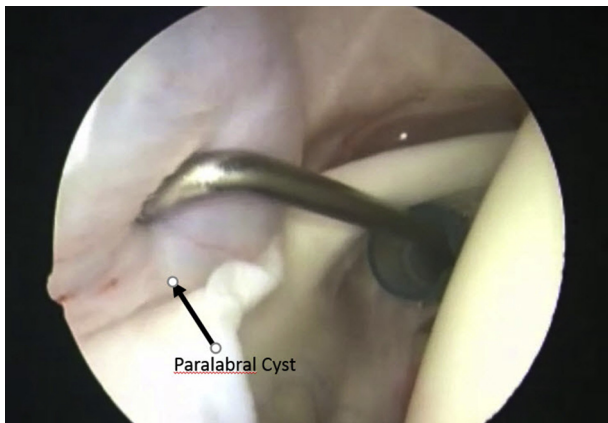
With visualization through the posterior portal with a 30° arthroscope with the patient in the beach-chair position, the probe is inserted through the anterior working portal through the rotator interval. In this case, the capsular tissue just posterior to the biceps origin is probed and manipulated to confirm the location of the paralabral cyst (arrow) just medial to the capsule. The location is determined from the reference point found on magnetic resonance imaging. Here, the probe can be seen to compress a fluid-filled mass just deep to the capsular tissue, which shows the most lateral margin of a posterior-superior paralabral cyst. This confirmation under direct visualization allows the surgeon to establish the location of the limited capsulectomy that is to be made to gain access to the cyst and decompress it.
